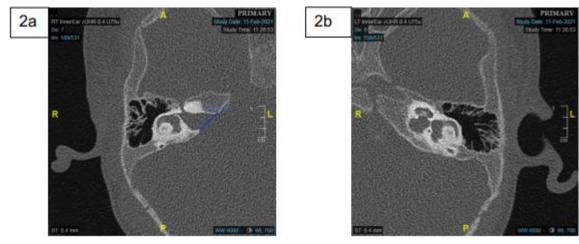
shows HRCT Temporal (Axial, Bone Window)
